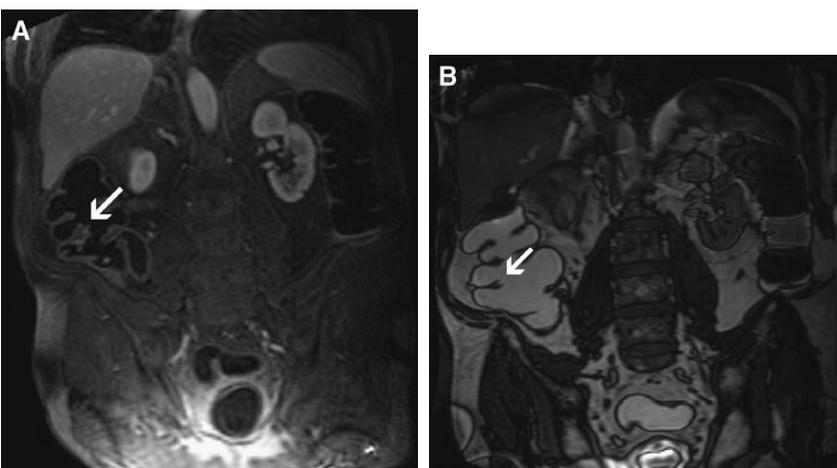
Fast imaging with steady-state precession sequences may provide useful information. (A) On the T1-weighted image, a thickened haustral fold is shown (arrow). (B) This turns out to be a motion artifact (arrow), because the TrueFISP scan shows no abnormality.
